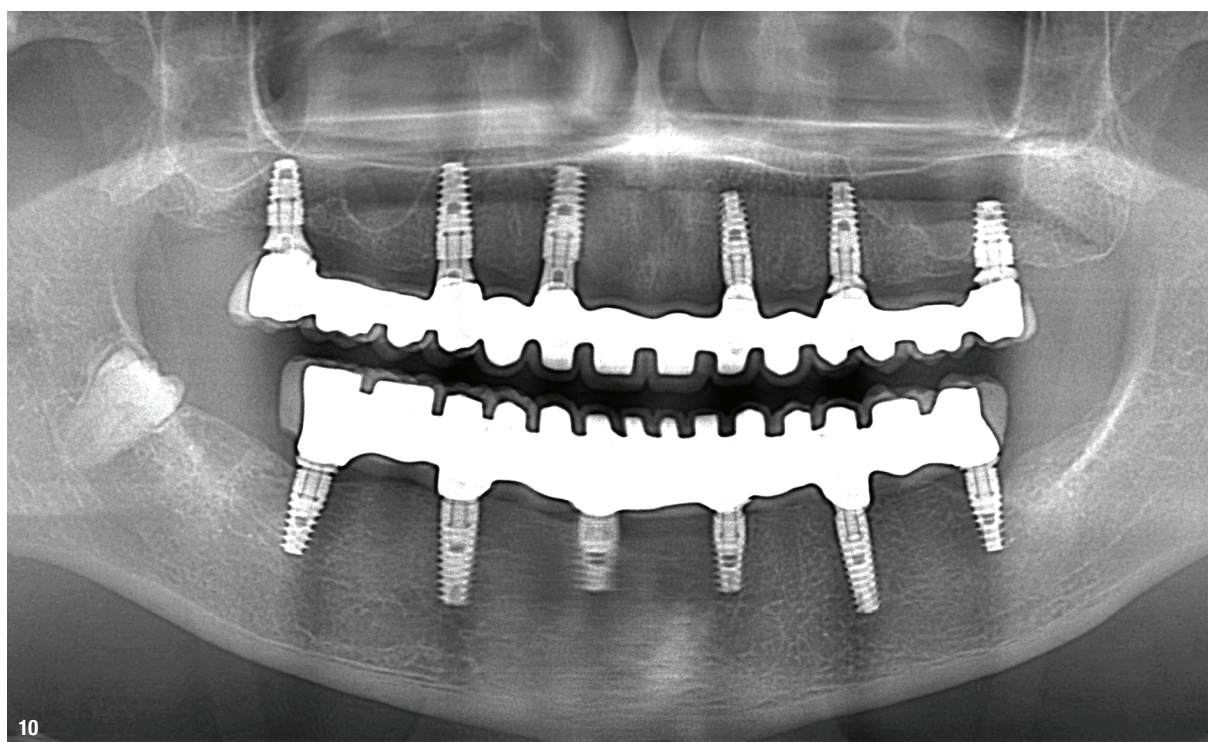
Radiographic examination five years after placement and restoration of the implants.
